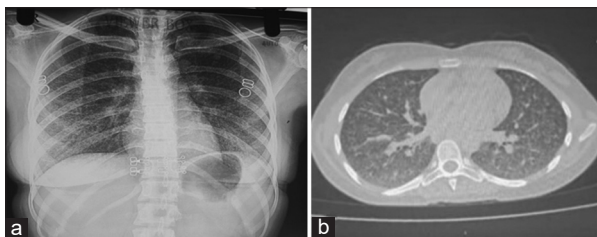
(a) Chest X-ray showing diffuse, uniformly distributed miliary nodules; High-resolution computed tomography thorax showing randomly distributed micronodules consistent with miliary tuberculosis
